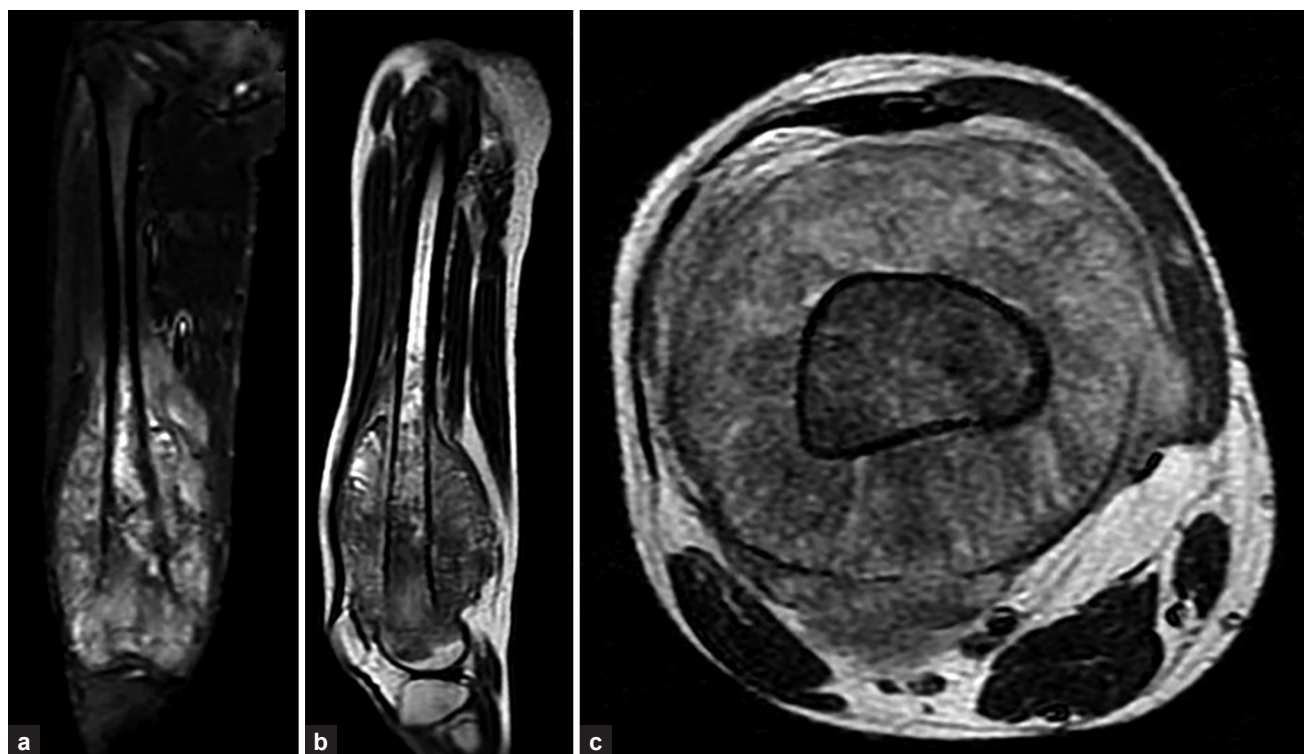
(a to c) Magnetic resonance imaging (MRI) of osteosarcoma distal end of femur. (a) T2-weighted coronal image; (b) T1-weighted sagittal image showing intramedullary extent and extraosseous soft tissue component without involvement of knee joint; (c) T2-weighted axial image showing large extraosseous component and free neurovascular bundle
